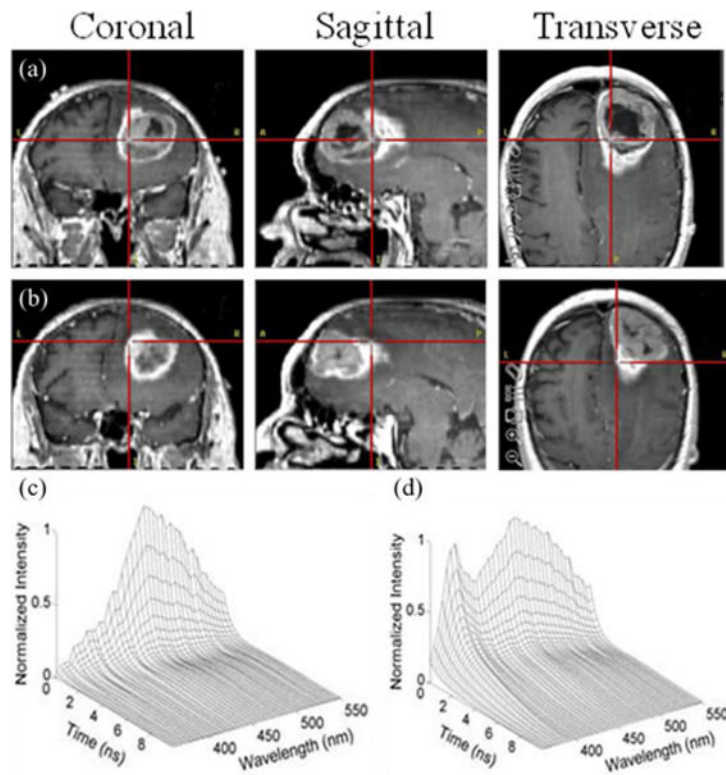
Initial identification of areas of interest for TRFS interrogation based on preoperative MRI images. (a) Area within tumor. (b) Area at the tumor margins; typical TRFS point measurement (deconvolved data) from (c) LGG and (d) NWM.
